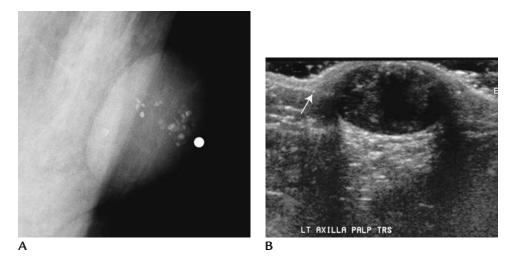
Sebaceous cyst. (A) Spot tangential view demonstrating an oval, circumscribed, isodense mass with associated calcifications corresponding to a palpable finding (metallic BB) in the left axilla. Sebaceous cysts can arise anywhere; however, they are more common in the inner quadrants and axillary regions. (B) On ultrasound, an oval, circumscribed mass with posterior acoustic enhancement and a heterogeneous echotexture related to the presence of calcifications associated with the dermis is imaged corresponding to the palpable finding. Note interruption of the deep dermal layer (*arrow*) commonly seen with lesions arising and expanding the skin.
